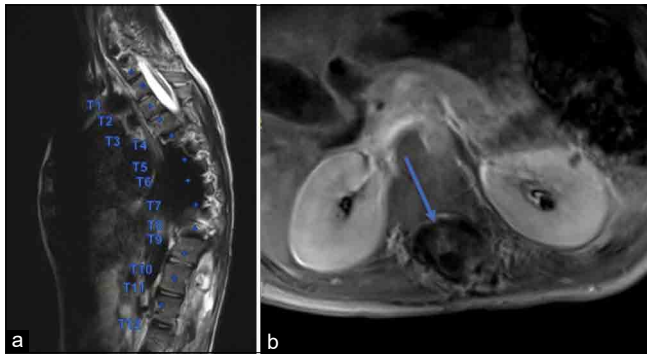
Interval postoperative MRI obtained to evaluate for tumor recurrence or progression revealed new enhancing 6 mm nodule at level of T11/12, deemed clinically insignificant in context of progressive kyphoscoliosis and stable in appearance on subsequent MRIs. (a) T2 noncontrast image of thoracic spine in sagittal plane, with evidence of significant coronal deformity as well as T2 hyperintense cystic lesions in the lower thoracic spine. (b) T1 postcontrast image of the thoracic spine at the inferior aspect of T11 with evidence of enhancing nodule (blue arrow).
